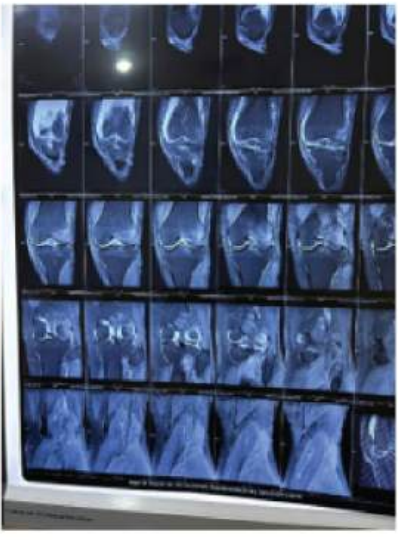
Sagittal section right knee joint MRI
